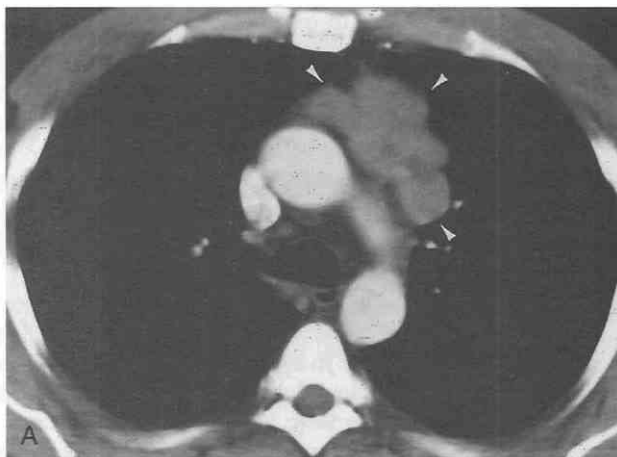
Invasive thymoma with pleural metastases. A and B, Contrast-enhanced CT shows lobular heterogeneous mass (arrowheads in A) in anterior mediastinum. Noncontiguous pleural metastases ("drop metastases") (arrowheads in B) are present in the left hemithorax.
